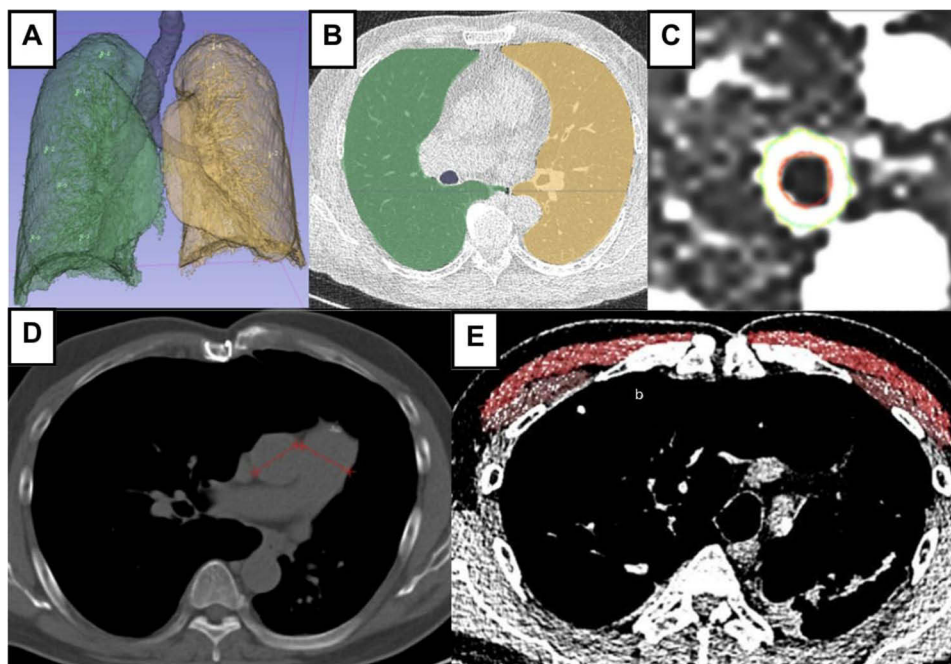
QCT evaluation using 3D slicer software. (A and B) Density evaluation based on %LAA₋₉₅₀ after lung segmentation to define emphysema. (C) Airway evaluation in the third generation of the right lung resulting in %WA. (D) An HRCT axial view, mediastinum window to measure PA:A ratio and (E) Measurement PMA and PMD on the level right above the aortic arch showing pectoralis muscle segmentation (bright red = major pectoralis muscle; brownish red = minor pectoralis muscle). Abbreviations: QCT, quantitative CT scan; HRCT, high-resolution CT scan; %LAA₋₉₅₀, percentage of lung attenuation area <-950 HU; %WA, wall area percentage; PA:A ratio, pulmonary artery-to-aorta ratio; PMA, pectoralis muscle area; PMD, pectoralis muscle density.
